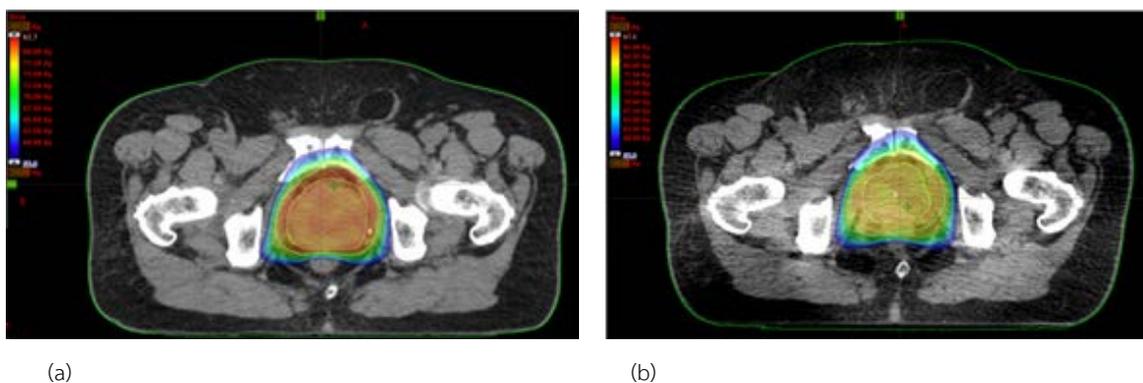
The dose distribution of VMAT prostate plan (a) PCT-based dose calculation and (b) CBCT-based dose calculation in patient no.5.
